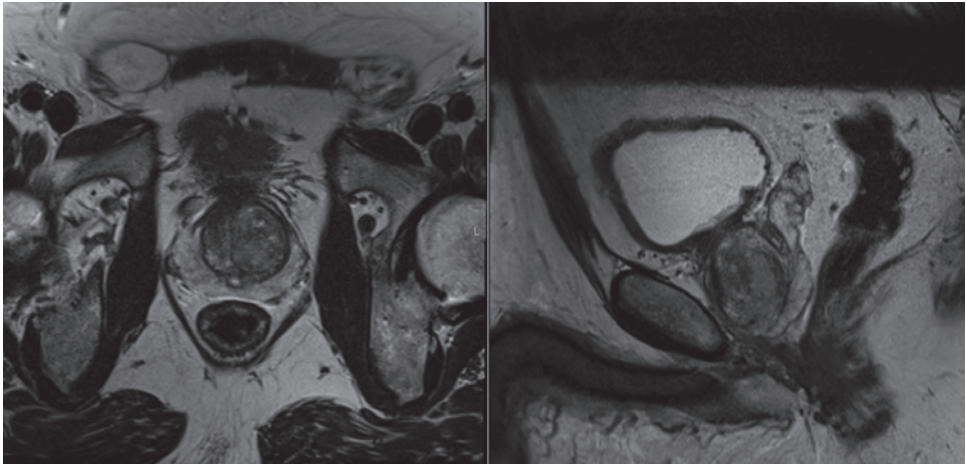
Axial and sagittal T2 weighted MR imaging of the prostate
